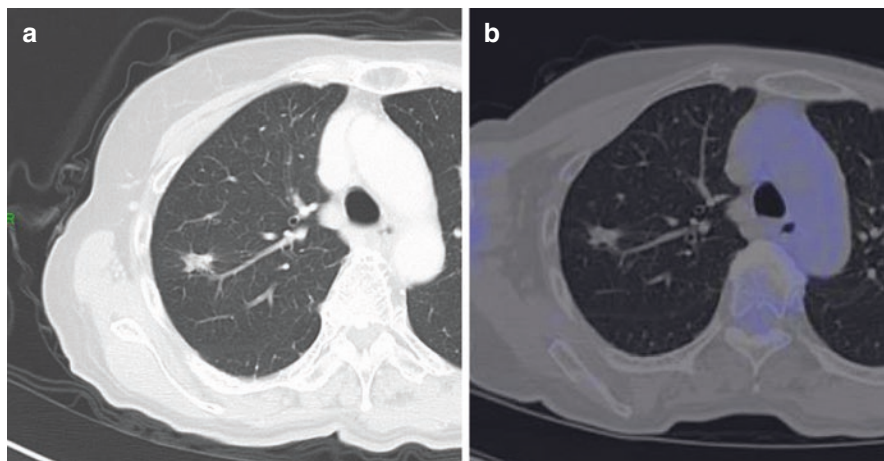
A 60s' female with nonmalignant pulmonary lesion. (a) A high-resolution CT image shows an irregular shaped lesion in the upper lobe of the right lung. Lung cancer cannot be ruled out. (b) An FDG/PET fusion image shows faint uptake in this irregular-shaped lesion, suggesting its low metabolic activity. Surgical resection confirmed the diagnosis of no malignancy 2 years later
